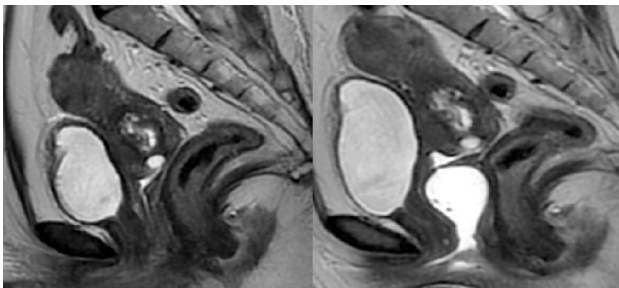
MRI T2 weighted Sagittal Images before and after gel instillation: Endovaginal gel instillation technique demonstrates a thick wedge shaped complete vaginal septum along proximal aspect causing vaginal distension, representing an obstructed vaginal septum.
